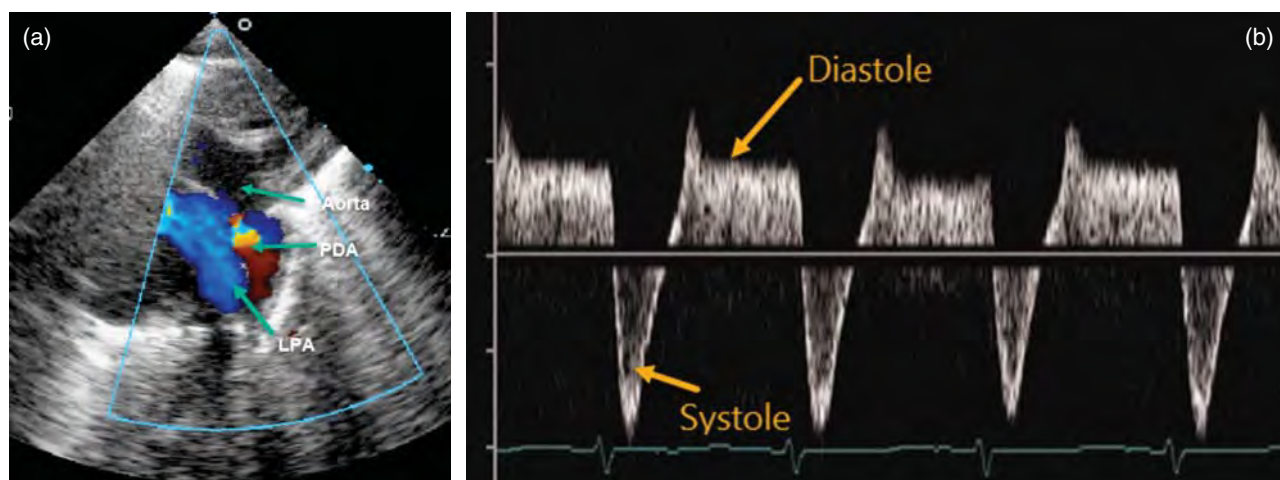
(a) Neonate with a moderate size PDA and with some degrees of elevated pulmonary resistance. (b) Spectral Doppler image also demonstrates bidirectional shunt (right to left during systole and left to right during diastole) but with this time with predominantly left to right shunt.
